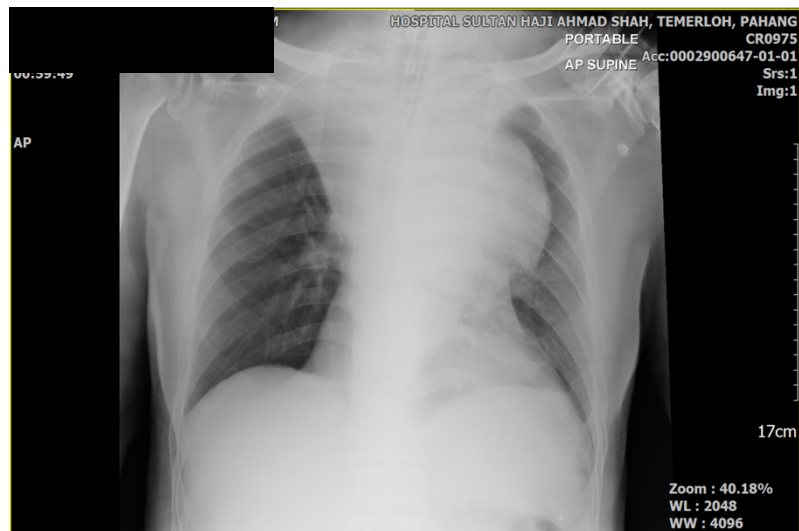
Chest radiograph of patient.
